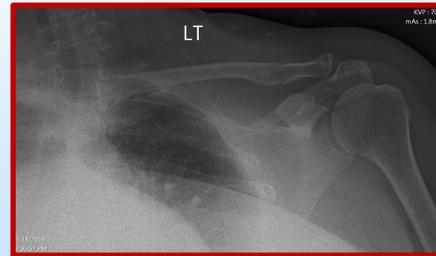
X-ray showing clavicular fracture
